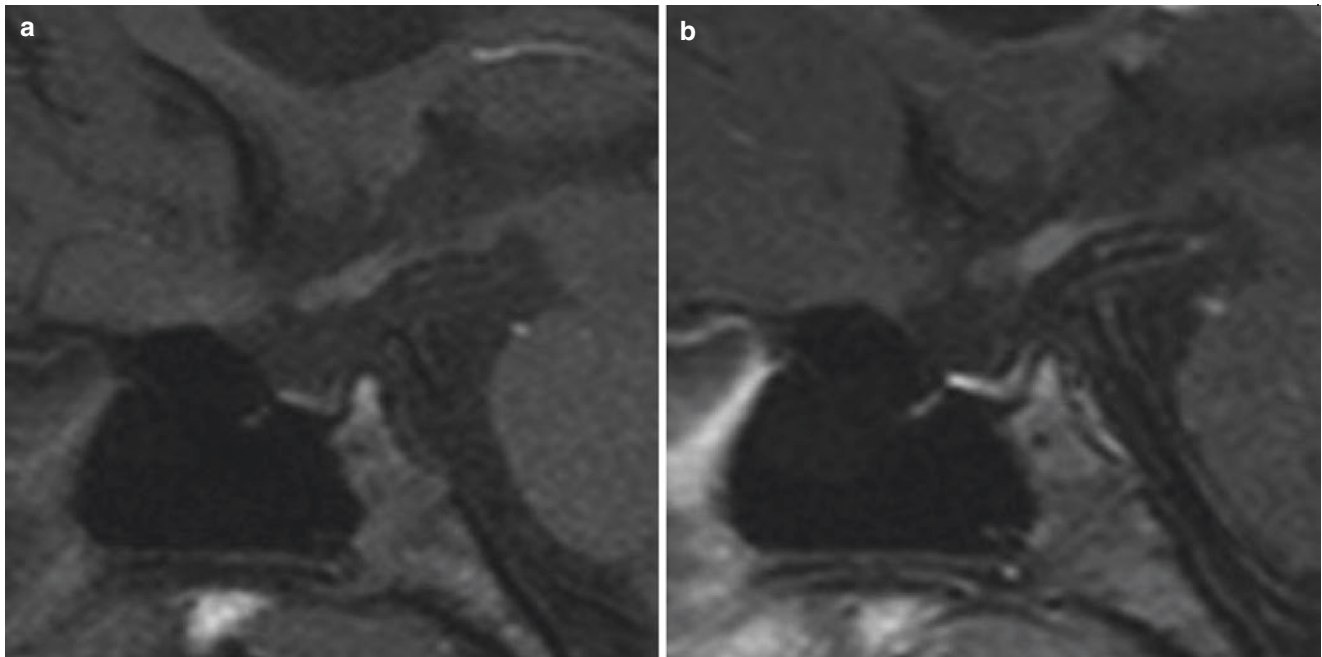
Pituitary gland hypoplasia. (a) Sagittal T1-weighted image pre-gadolinium and (b) post-gadolinium injection shows a small sella turcica, with a small pituitary gland and the absence of the characteristic T1 bright spot related to the neurohypophysis
